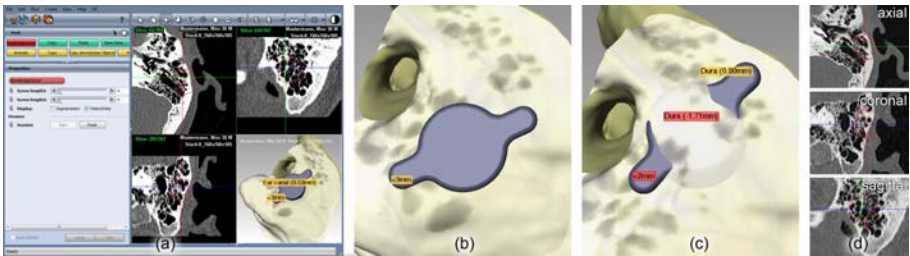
Screenshot of the BoneBridgeViewer application in ZIBAmira (a). Examples of invalid implant positions: cortical coverage of one screw below 2 mm (b) and penetration of dura by FMT (red label) (c). CT intersection with implant (d).
